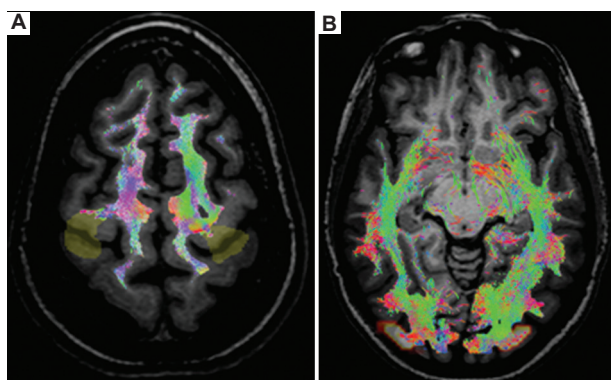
Tracts generated from activated areas in functional magnetic resonance imaging. In patient 2, activations induced by hand movements and vision were localized in typical areas, and their regions of interest gave rise to tractographies of the corticospinal tracts (A) and optic radiation (B).
